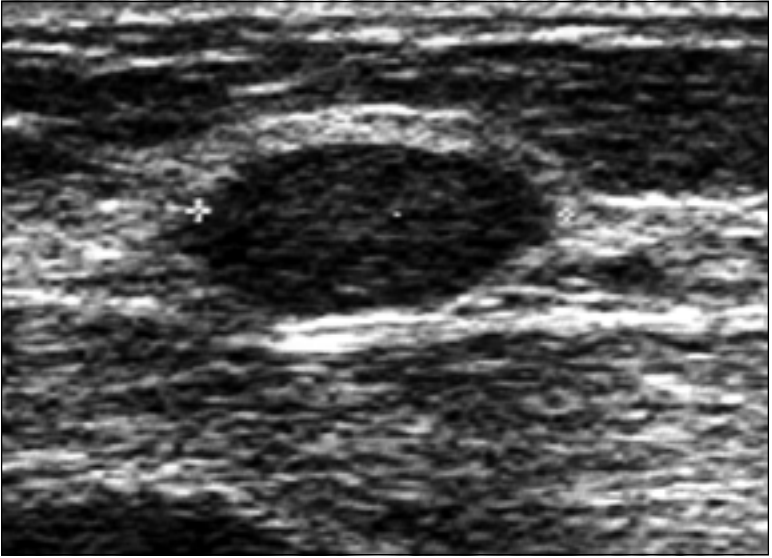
Ultrasound of a typical fibroadenoma appearing as an oval, well-defined nodule with uniform internal echo patterns.
